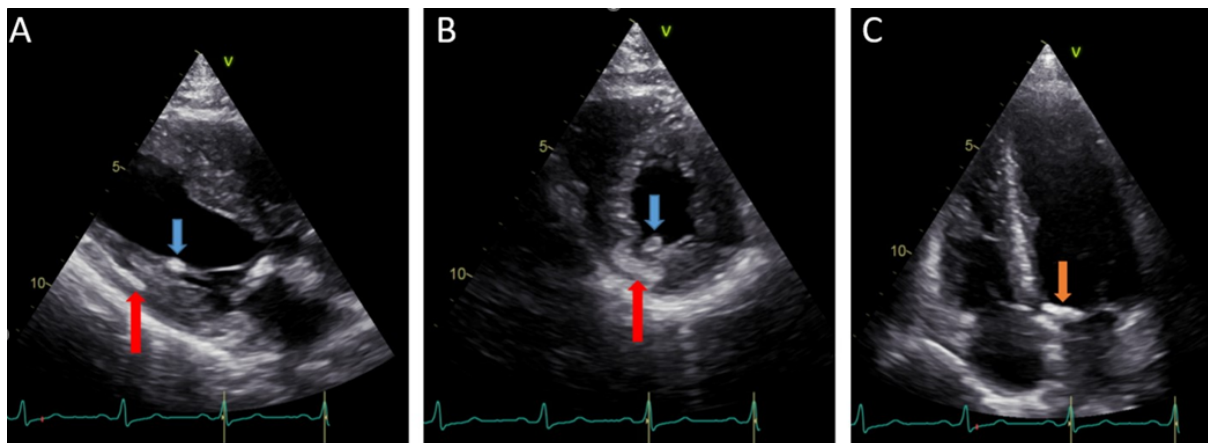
Findings of intracardiac calcification on transthoracic echocardiography. (A) In the parasternal long-axis section, myocardial calcification (red arrow) is seen in the inferolateral wall and a calcified focus (blue arrow) is seen in the posterior papillary muscle. (B) In the parasternal short-axis section, widespread calcification (red arrow) is seen in the inferolateral segment and nodular calcification (blue arrow) is seen in the posterior papillary muscle. (C) In the apical four-chamber section, prominent calcification is noted in the posterior part of the mitral annulus (orange arrow). These findings are consistent with fibrocalcific changes that were initially confused with an intracardiac mass, but were understood to have developed secondary to a silently experienced myocardial infarction with advanced imaging techniques.
